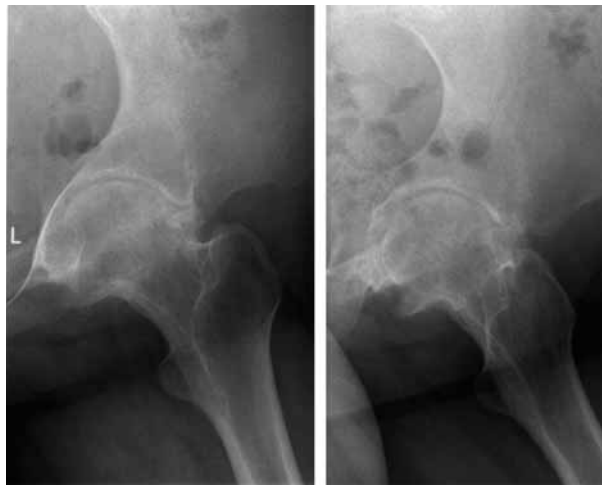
Radiograph of the left hip on admission in our institution, showing severe destructive arthritis of the left hip. The articular cartilage has almost vanished and there are signs of severe destruction of the subchondral bone.
